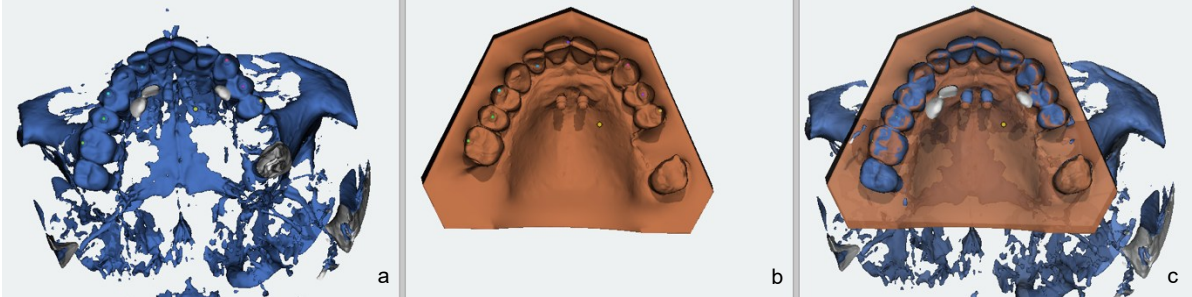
Superimposition (c) of postoperative CBCT dataset (a) and preoperative planning model (b) using the point to point function
